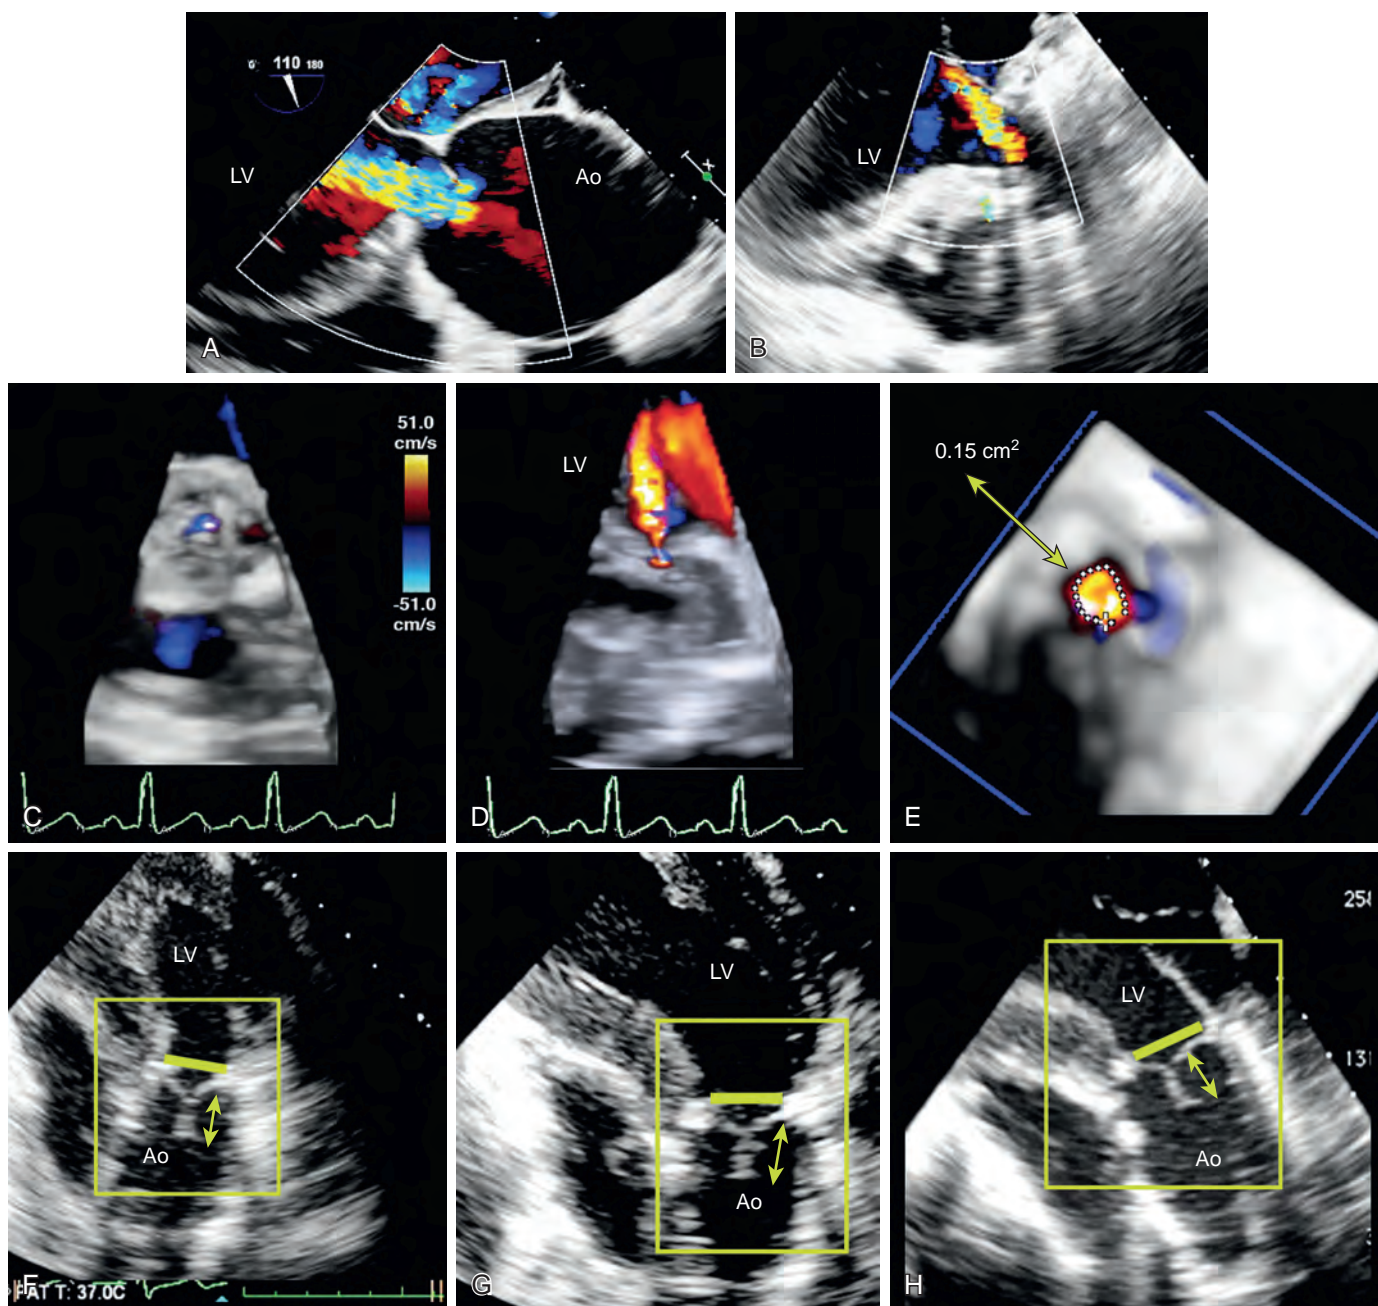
Aortic insufficiency (AI) and repair. These images demonstrate the benefits of performing a comprehensive echocardiographic exam using different ultrasound modalities and both transesophageal and gastric windows. (A) Prerepair and (B) postrepair midesophageal long-axis color Doppler views show significant AI. Postrepair image shows a significant color Doppler profile but the valve is not well seen. (C) Midesophageal and (D) and (E) transgastric windows, three-dimensional volumetric color data sets allow visualizations of the regurgitant jet below, at, and above the valve. (D) Narrow jet of insufficiency at the valvular level, which expands due to entrainment. Editing the data set allows planimetry of the regurgitant jet, which measures 0.15 cm^2 in area consistent with mild AI. (F–H) Transgastric two-dimensional images allowing visualization of the coaptation level (ie, no residual prolapse; solid line) and coaptation length (arrows-line). Ao, Aorta; LV, left ventricle.
